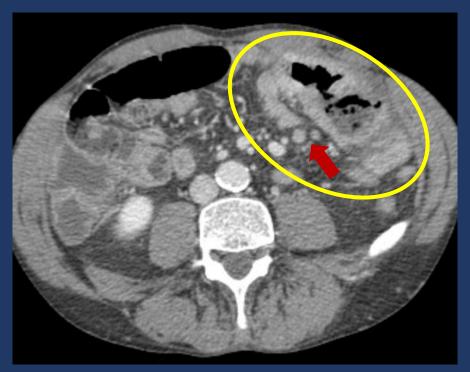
CT image demonstrate a circumferential thickening of jejunal wall (circle) with luminal dilatation and small adjacent adenopathies (arrow). This proved to be an adenocarcinoma.
